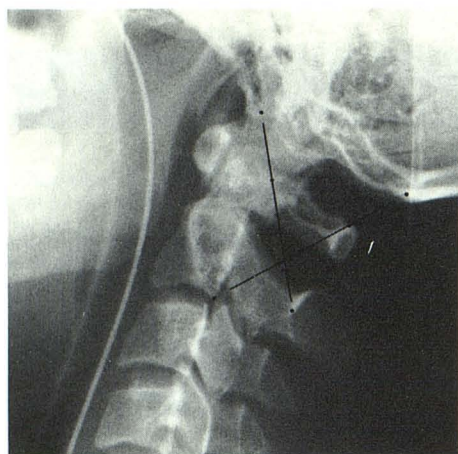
Normal lateral cervical radiograph with X lines applied. BC2SI line is drawn from tip of basion (B) to midpoint of C2 spinolaminar line (SI). This line just intersects with posterosuperior margin of dens. The C2O line is drawn from posteroinferior corner of body of C2 to tip of opisthion (O). This line just intersects with highest point of C1 spinolaminar line.
